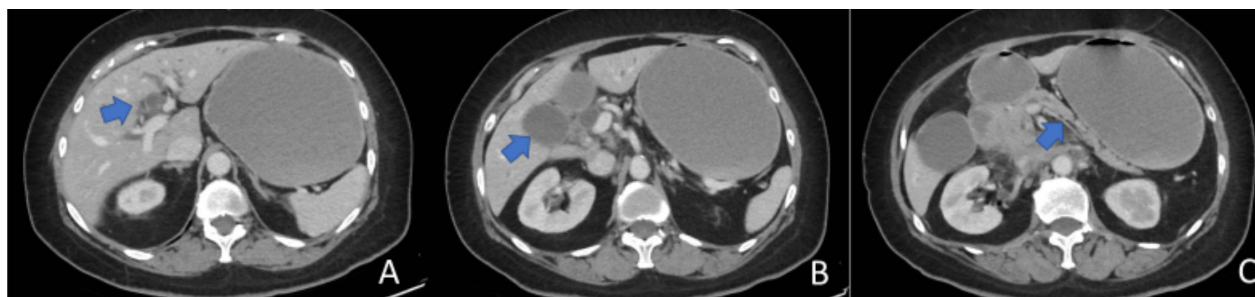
CT scan of abdomen shows mass at duodenum causing marked gastric dilatation, dilatation of intrahepatic duct (A), gall bladder (B) and pancreatic duct (C).
